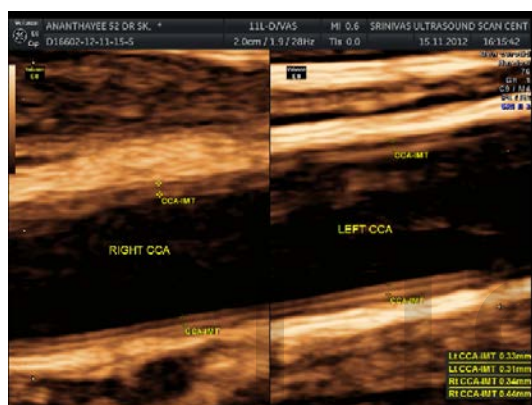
True colour ultrasound image of the common carotid artery (both right and left) manually annotated by the medical practitioner.
